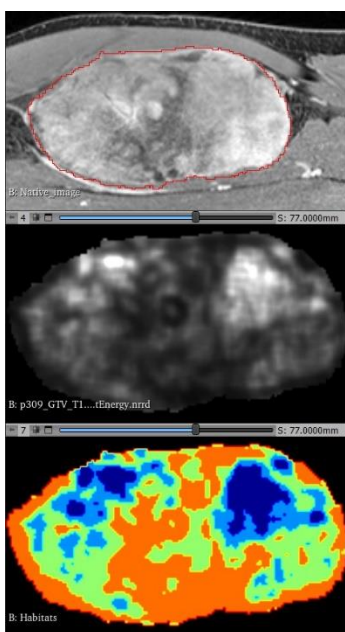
Native T1-weighted gadolinium enhanced Dixon-water image (up) with its GLCM -Joint Energy corresponding map (middle) and the habitat maps (down). The gross tumor volume is segmented in red. The habitat 1 to 4 are depicted from orange to dark blue, respectively.
